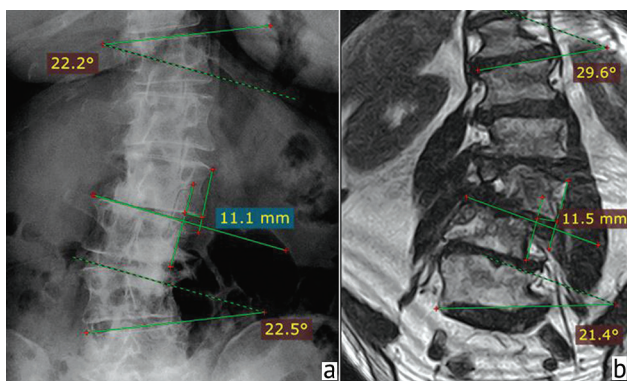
X-ray of the lumbar spine in the direct projection (a); MRI scan (T2-WI) of the lumbar spine in the frontal plane (b) in an upright position. There is a difference in the values of the angles of scoliotic deformity
